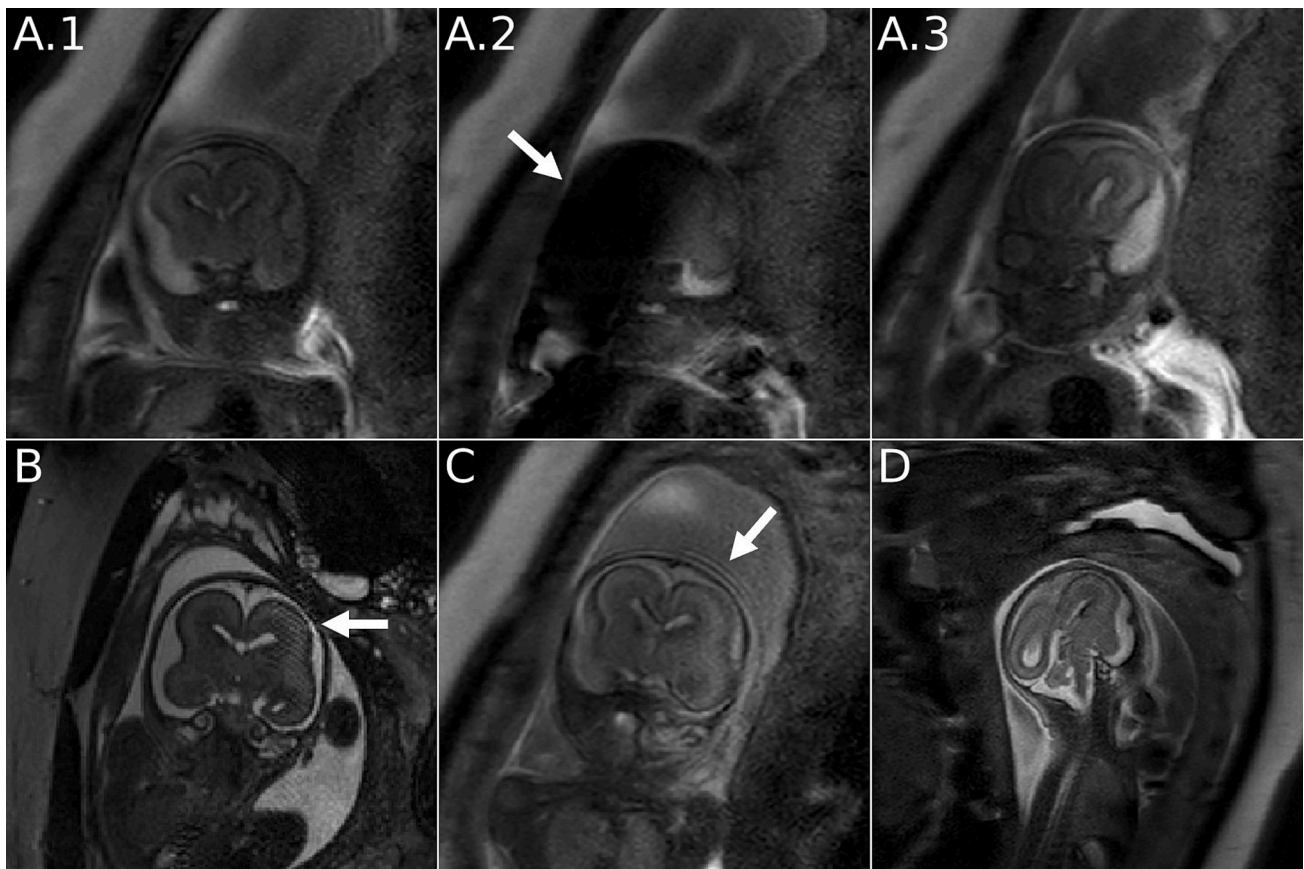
Artifacts on fetal MR images. Motion artifacts are visible in consecutive acquired slices (A.1 - A.3). Intensity artifacts, ringing artifacts, and no standard acquisition orientation effects are visible in boxes B, C, and D, respectively.
